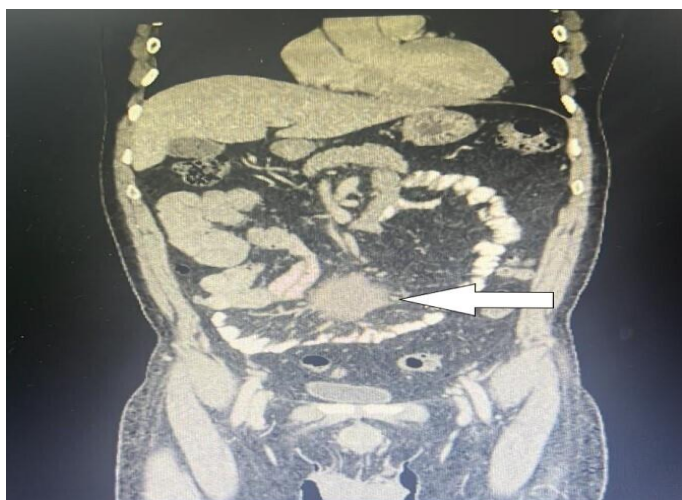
CT scan reveals lobulated, enhancing mass in the mesentery of the central abdomen.
